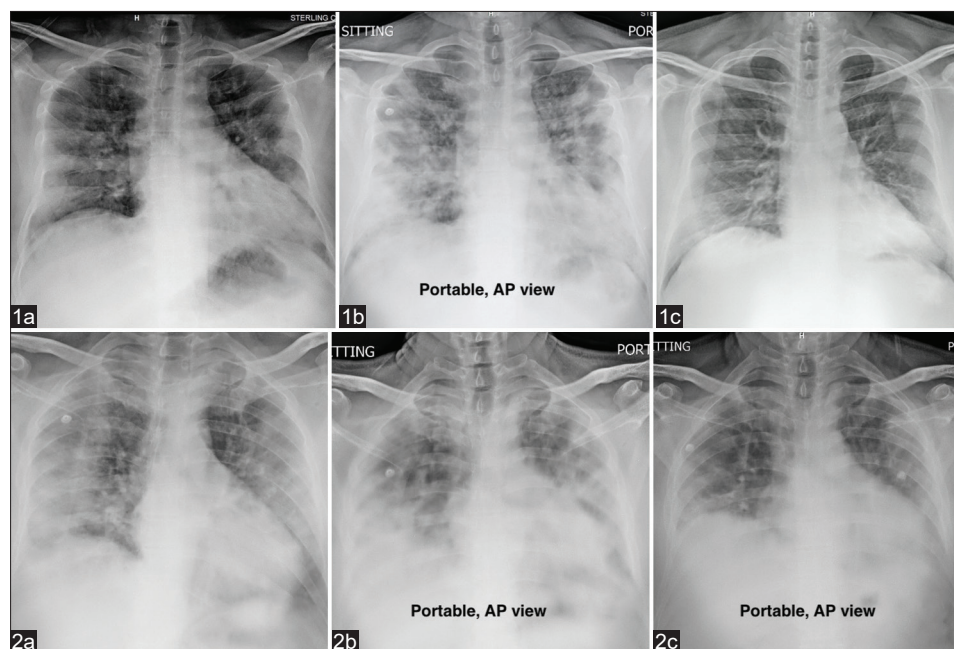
Serial Chest X-ray chest of patients after tocilizumab. Patient # 12: (1a) Day of Tocilizumab administration, (1b) After 1 week of Tocilizumab, (1c) At the time of Discharge. Patient #17: (2a) Day of Tocilizumab administration, (2b) After 1 week of Tocilizumab, (2c) At the time of Discharge
